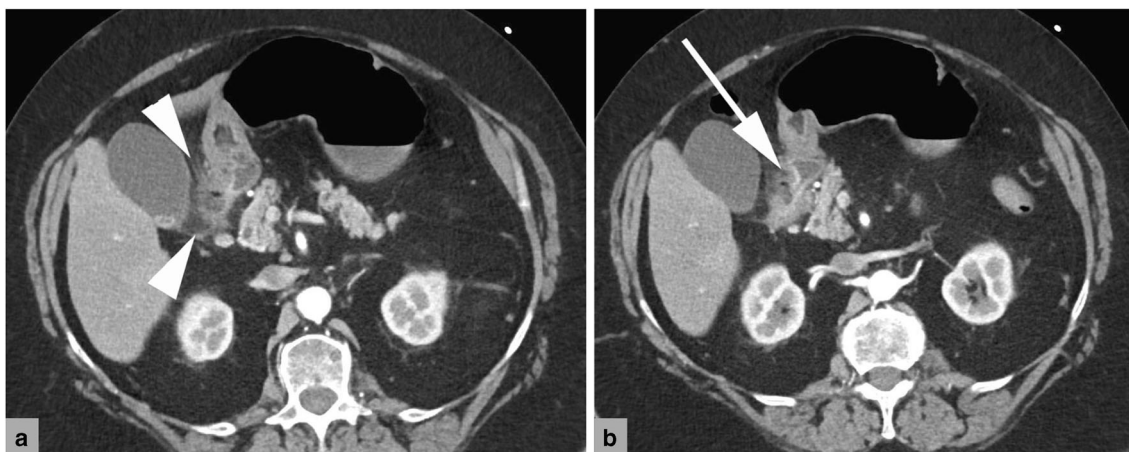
Eighty-one-year-old woman with contained perforation from duodenal ulcer. a Axial IV contrast-enhanced CT shows periduodenal stranding and small periduodenal collection (arrowheads). b Use of thin sections enables delineation of communication with duodenal lumen
